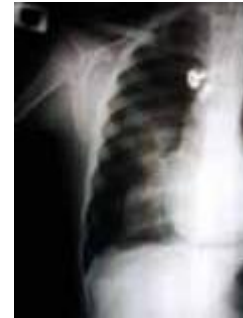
(a/b). Bilateral pneumothorax and bilateral apical subcutaneous emphysema in PA radiograph of chest after intubation
